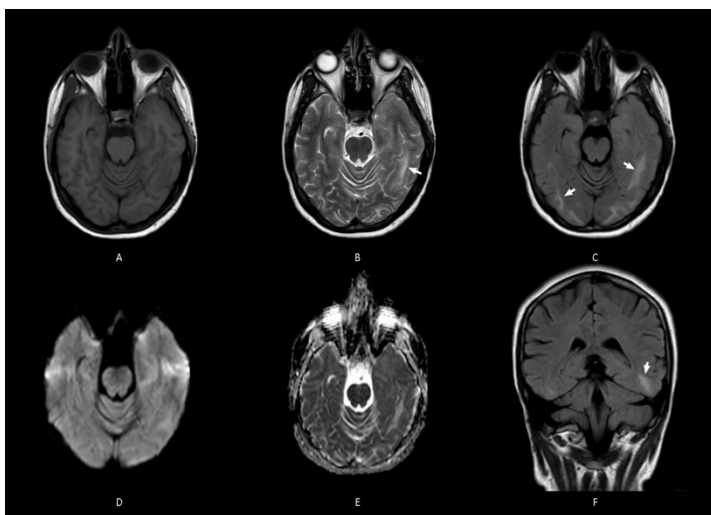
Shows cranial magnetic resonance imaging demonstrating parieto-occipital region PRES findings. Axial (A), coronal (C), and axial (F) plan FLAIR sequences (arrows); (B) hyperintense signal property on T2-WI; (A) hypointense on T1-weighted imaging (WI). Diffusion weighted imaging (D) and apparent diffusion coefficient images (E) did not exhibit any diffusion restriction
